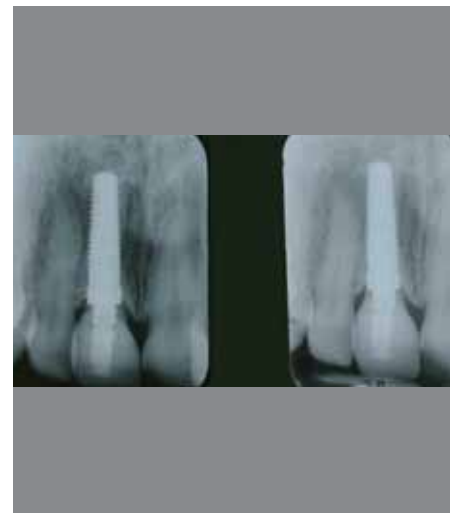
Final x-ray after one and three years.
